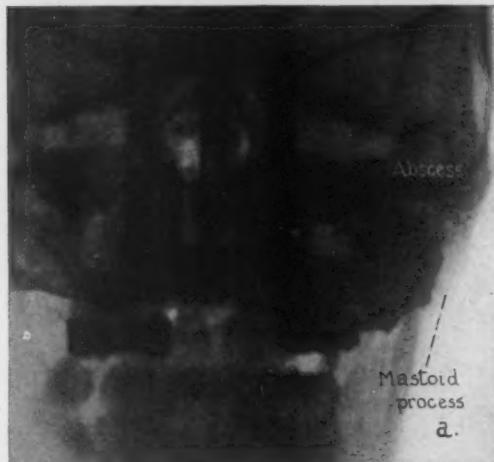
Roentgenograms after injection of 15 c.c. lipiodol. (a) Posterior-anterior view. (b) Lateral view showing abscess cavity and sinus tract.
